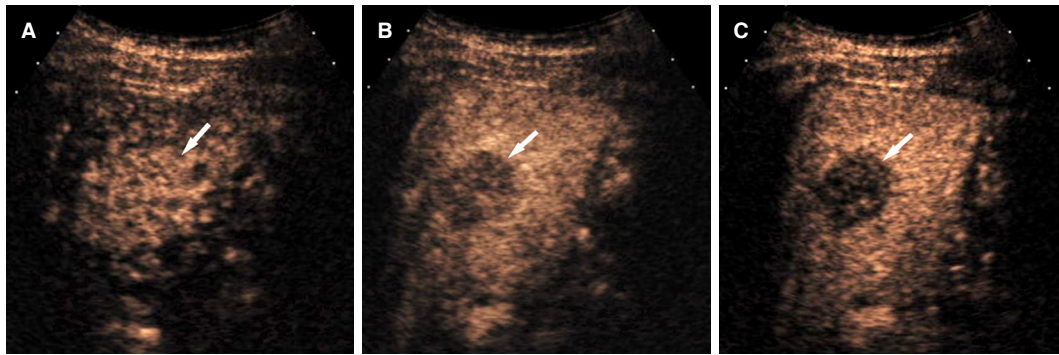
Combined hepatocellular-cholangiocarcinoma in a 77-year-old man with hepatitis-B related liver cirrhosis. A: contrast-enhanced CT or MRI could not be performed due to renal failure. CEUS in the arterial phase shows a mass with homogeneous arterial phase hyperenhancement (arrow); B: CEUS at 31 s after contrast injection shows early washout (arrow); C: CEUS at 60 s after contrast injection shows marked washout (arrow). CEUS: contrast enhanced ultrasound
